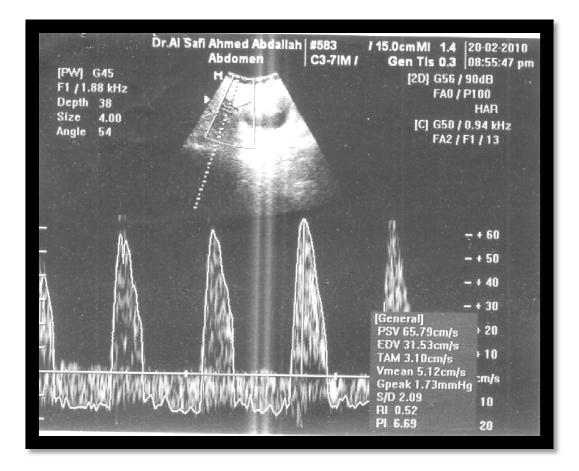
Color Doppler scan for a 41 patient with a history o(f RPL) the Sagittal abdominal scan shows a complete abortion
